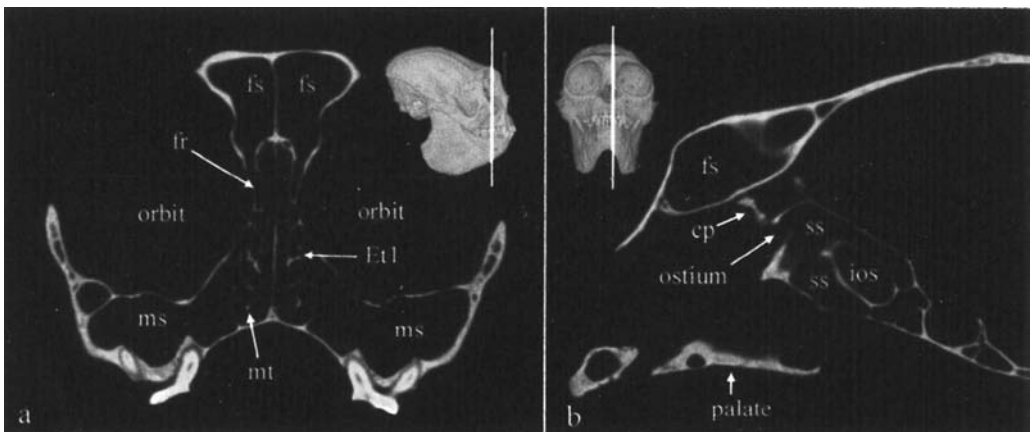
Coronal (a) and parasagittal (b) CT-scans of the platyrrhine *Callicebus* showing maxillary (ms), frontal (fs), and 'sphenoid' sinus (ss). White lines in scout images (insets) indicate plane of each scan. cp, cribriform plate; Et1, first ethmoturbinal; fr, frontal recess; ios, interorbital septum; mt, maxilloturbinal.
